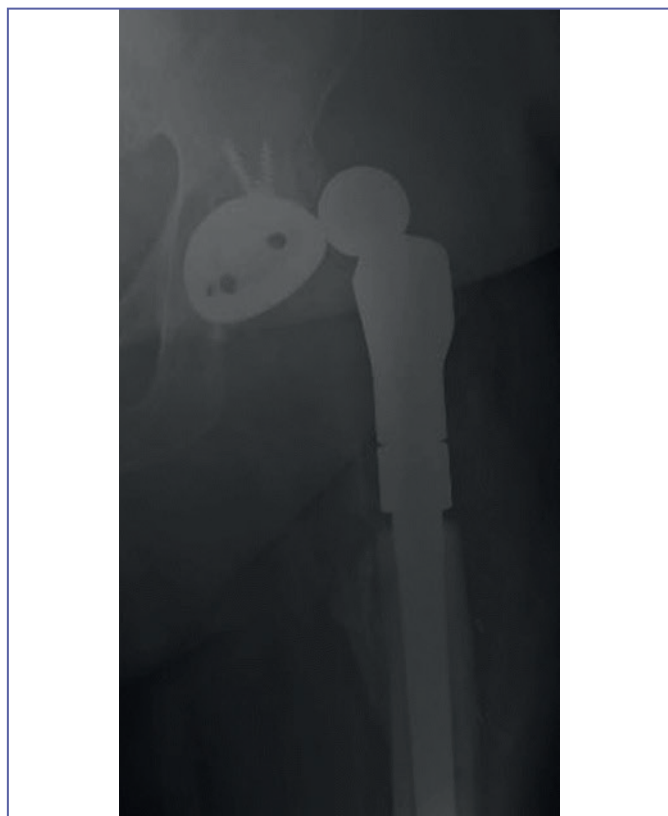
Proximal femur nonunion treated with modular endoprosthesis. A) pre-operative x-rays; B) post-operative x-rays.
